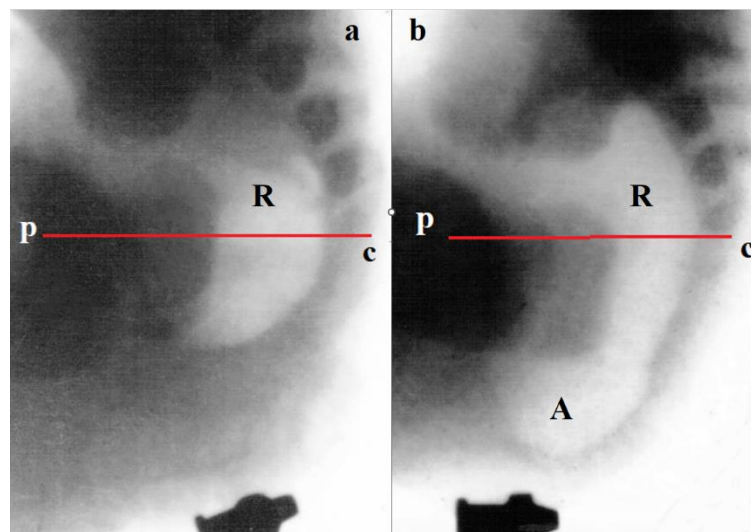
X-ray study of a newborn with abdominal compression. The cannula from needles is taped near the anal dimple. (a). At the beginning of compression, gas from the rectum (R) began to enter the anal canal. (b). And immediately the caudal wall of the anal canal (A) approached the marker near the anal dimple. The anal canal contracted and gas returned to the rectum as soon as abdominal compression stopped. This image indicates the absence of a functioning fistula and the possibility of performing a perineal perforation procedure (PPP).
